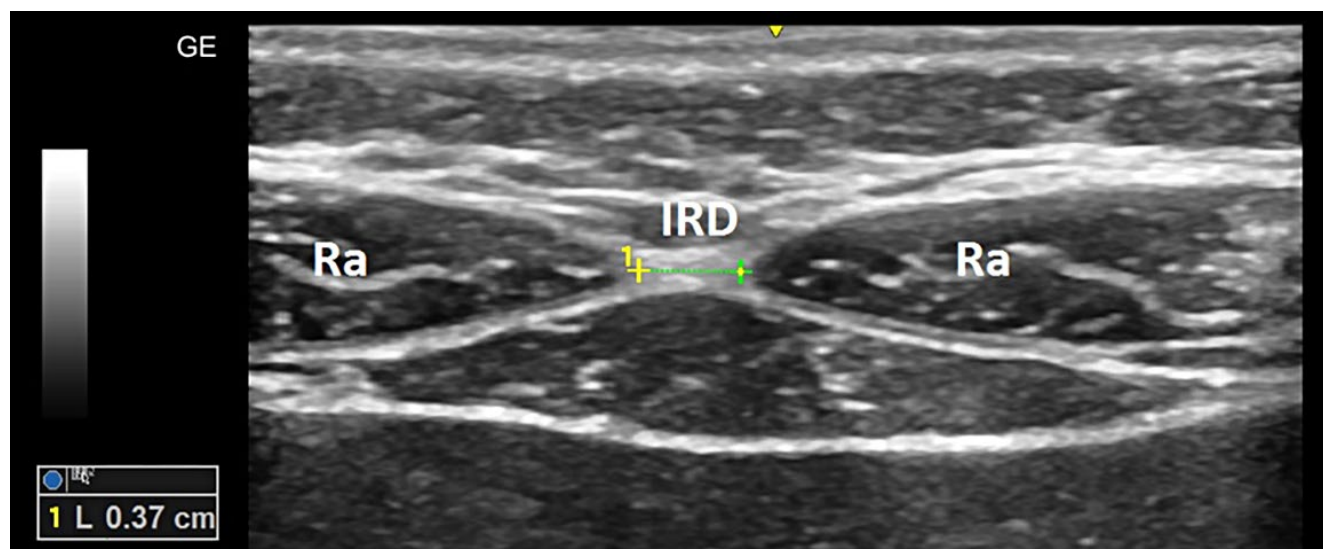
Measurements of the IRD using ultrasonography. IRD – interrectus distance; Ra – rectus abdominis muscle; IRD (L) = 0.37 cm (does not meet the criteria for diastasis recti)
